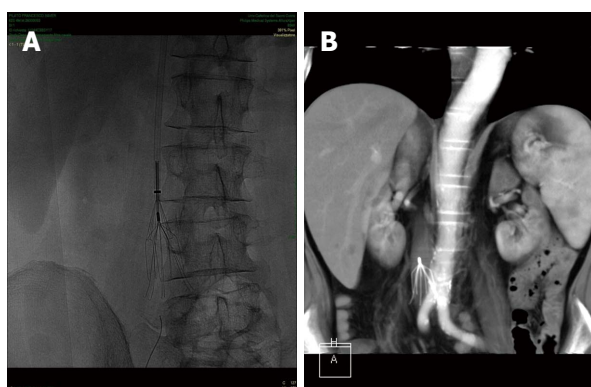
Plain abdominal Rx (A) and computed tomography scan (B) showing an inferior vena cava filter placed for the prevention of recurrent pulmonary embolism in a patient with Crohn's disease and deep venous thrombosis.
